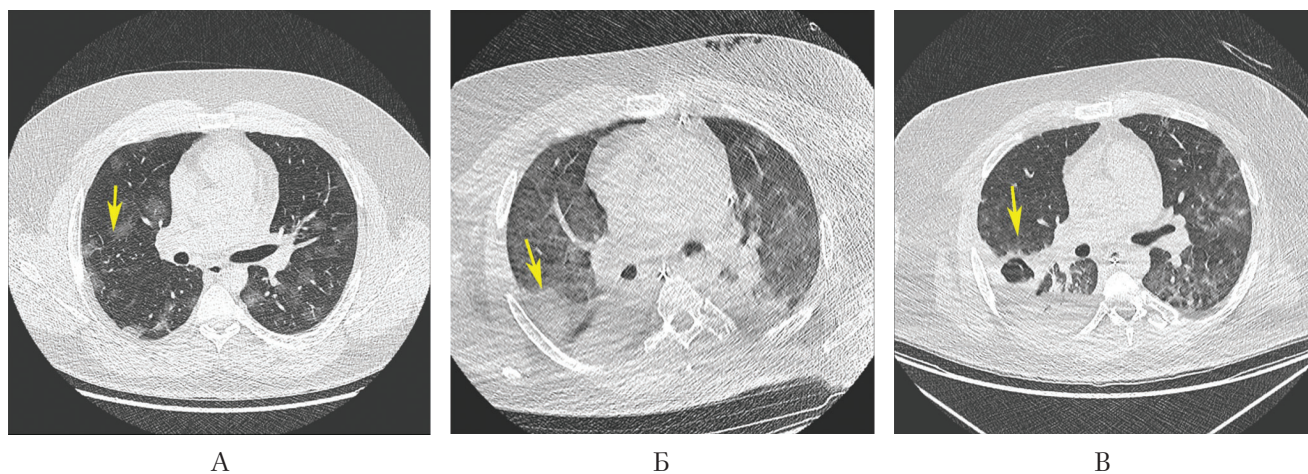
Follow-up of CT imaging of 32 y.o. patient with confirmed COVID-19 pneumonia, acute respiratory distress syndrome and cavitation and consolidation with cavitation in the right lung
